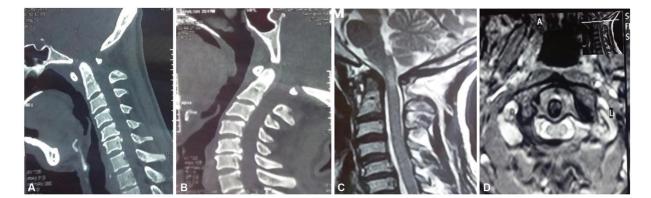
Preoperative noncontrast computed tomography (CT) craniovertebral junction (CVJ). (A) sagittal view showing atlantoaxial dislocation (AAD) in flexion, (B) reduction of AAD in extension, (C) T2-weighted (T2W) magnetic resonance imaging (MRI) CVJ sagittal view, and (D) axial cuts, showing anterior compression over cord with hyperintense changes in the cord at the CVJ region.
